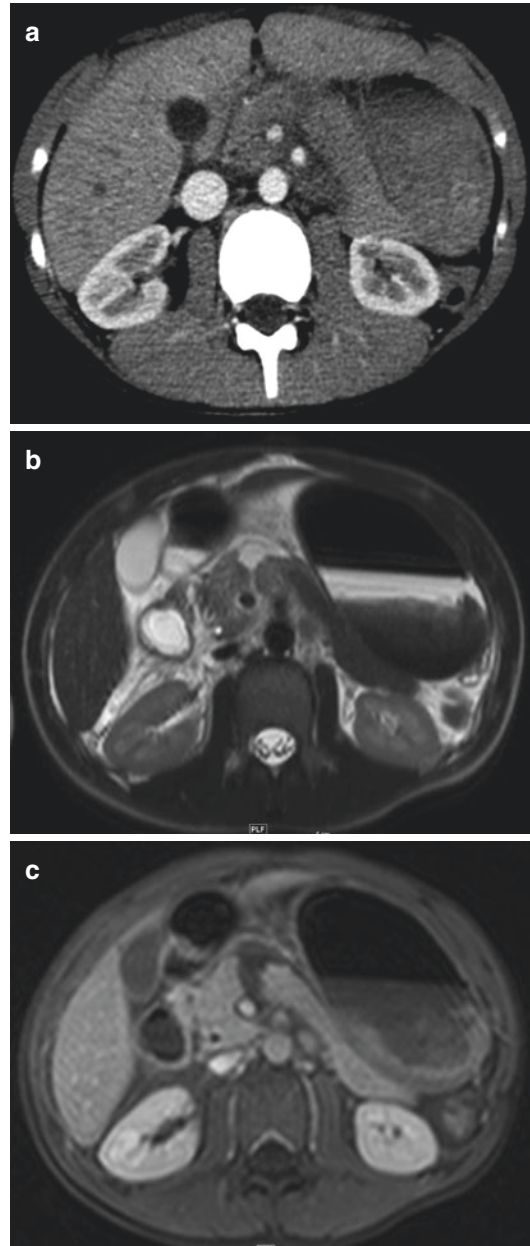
Fracture of the pancreas in a 5-year-old boy. (a) CE-CT 3 mm cut reveals a hypodense fracture in the mid-body of the pancreas. (b) MR imaging T2-weighted FS: the contrast between normal pancreatic tissue and fracture is better seen on the 4 mm T2 FS. (c) MR imaging T1-weighted fat saturation postgadolinium injection
